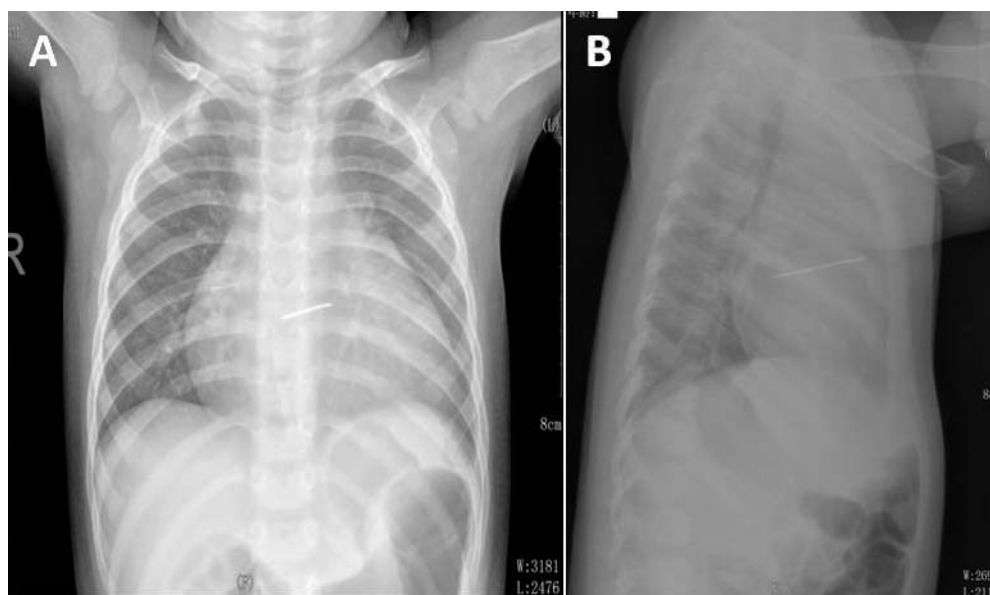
Chest X-ray examination showed a needle-shaped metallic density within the cardiac silhouette. (A) Postero-anterior view. (B) Left lateral view.
